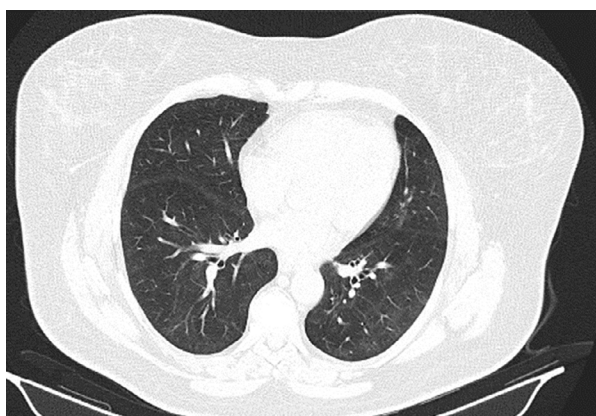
CT image demonstrates significant regression of bilateral COVID-19 lesions, with still visible ground-glass opacities in the same patient three months after discharge from the hospital.
